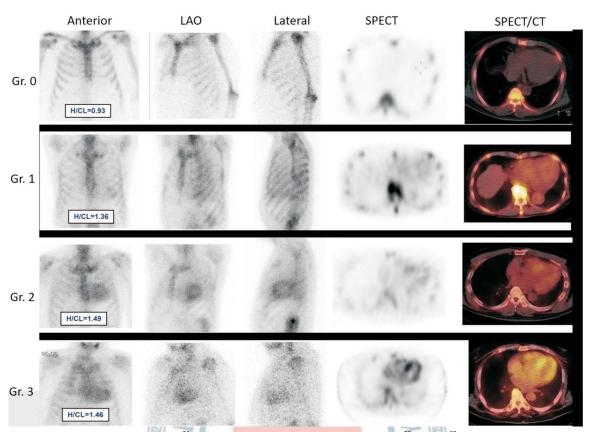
Visual scores from 0 to 3 based on ^{99m}Tc-PYP planar, SPECT, fused SPECT/CT images*, ^{99m}Tc-PYP, ^{99m}Technetium-labeled pyrophosphate; CT, computed tomography; Gr., Grade; LAO, left anterior oblique; ROI, region of interest; SPECT, single-photon emission computed tomography. * Modified with permission from Huang YH, Lin YH, Yen RF, et al. 2021 advocacy statements for the role of 99mTc-pyrophosphate scintigraphy in the diagnosis of transthyretin cardiac amyloidosis: a report of the Taiwan Society of Cardiology and the Society of Nuclear Medicine of the Republic of China. Acta Cardiol Sin 2021;37:221.
